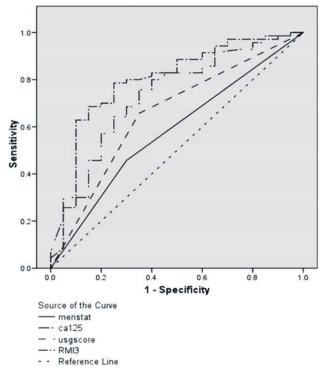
Receiver operator characteristic curve showing the performance of menopausal status, ultrasound score, serum Ca-125 level, and Risk of Malignancy Index (RMI 3).
